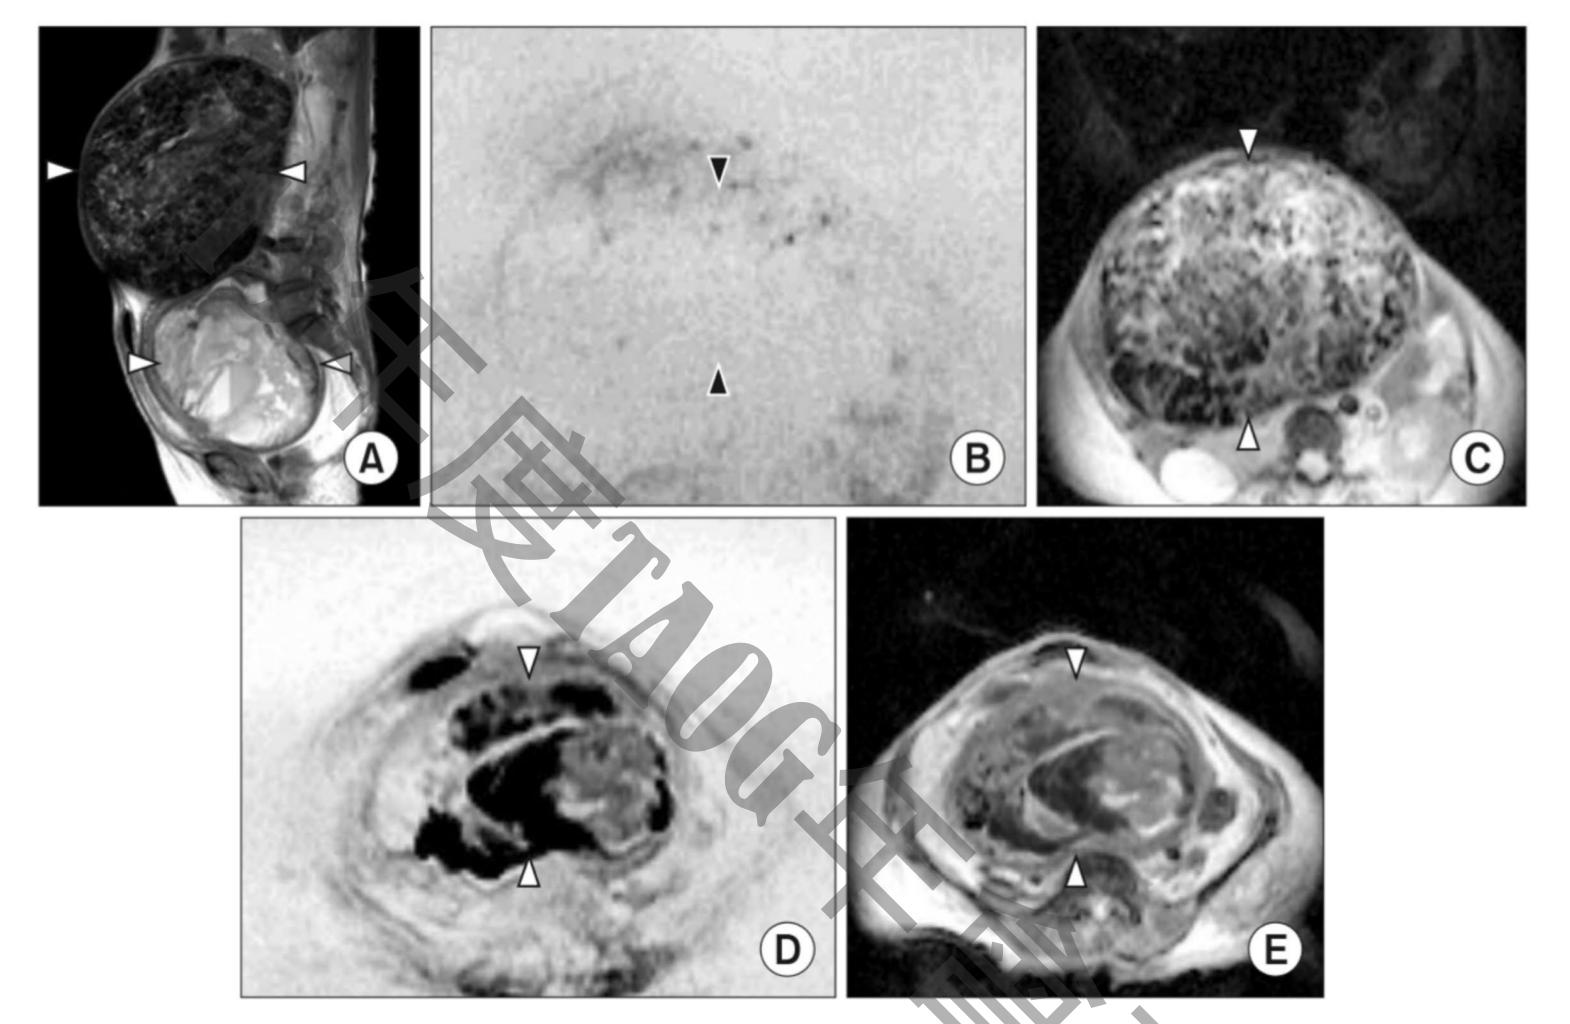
Uterine leiomyosarcoma and leiomyoma in a 72-year-old woman. Sagittal T2-weighted imaging shows an enlarged uterus with two solid lesions (arrowheads) (A). The upper lesion (arrowheads) shows low signal intensity on axial diffusion-weighted imaging (DWI) (B) and the apparent diffusion coefficient (ADC) map (C) demonstrated high ADC values (2.13×10⁻³ mm²/sec). The lower lesion (arrowheads) shows high signal intensity on axial DWI (D) and the ADC map (E) demonstrated low ADC values (0.67×10⁻³ mm²/sec). Pathological examination revealed leiomyoma in the upper lesion and leiomyosarcoma in the lower lesion.
